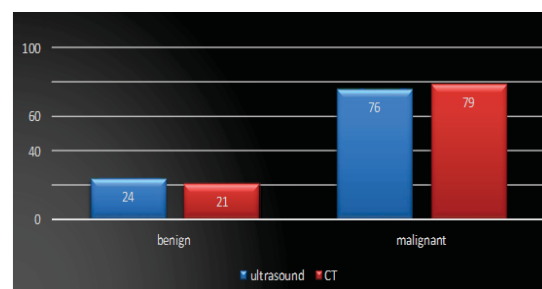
Comparison of USG and CT finding of nature of ovarian pathology
